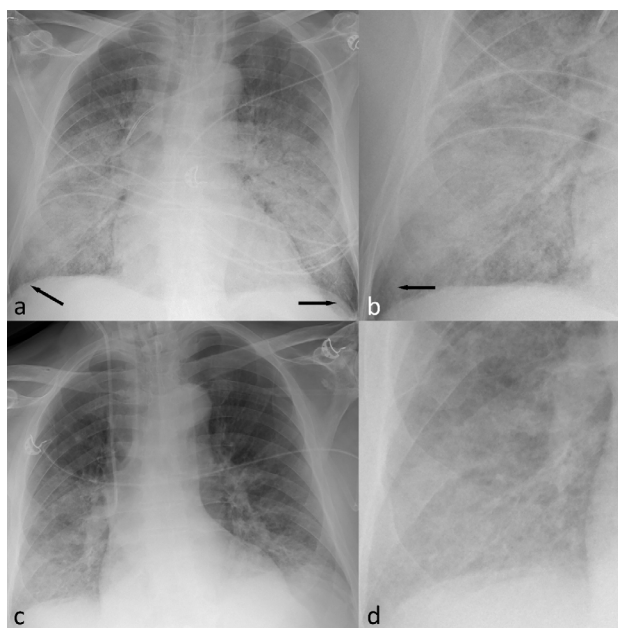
Two Supine plain chest radiographs in a.p. projection, taken during the first ICU admission when the patient presented with AIP (a-b) and during the second admission when the patient presented with DAH (c-d). (a) Symmetrically distributed GGO and airspace consolidations in the mid and lower lung segments with sparing of the costophrenic angles (arrows). (b) An enlarged view of the same radiograph (a), showing airspace consolidations and GGO. Note the sparing of the costophrenic angle (arrow). (c) Bilateral airspace consolidations and confluent GGO on the lower lung parts without sparing of the costophrenic angles. (d) An enlarged view of the same radiograph (c). a.p. = anteroposterior, AIP = acute interstitial pneumonia, DAH = diffuse alveolar hemorrhage, ICU = intensive care unit, GGO = ground glass opacities.
